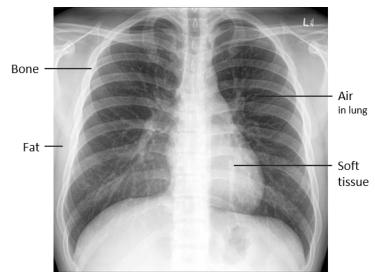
Radiograph of the chest. Radiographs differentiate structures of varying densities. Air is radiolucent (least dense, darker) where bone is radiopaque (most dense, brighter).
